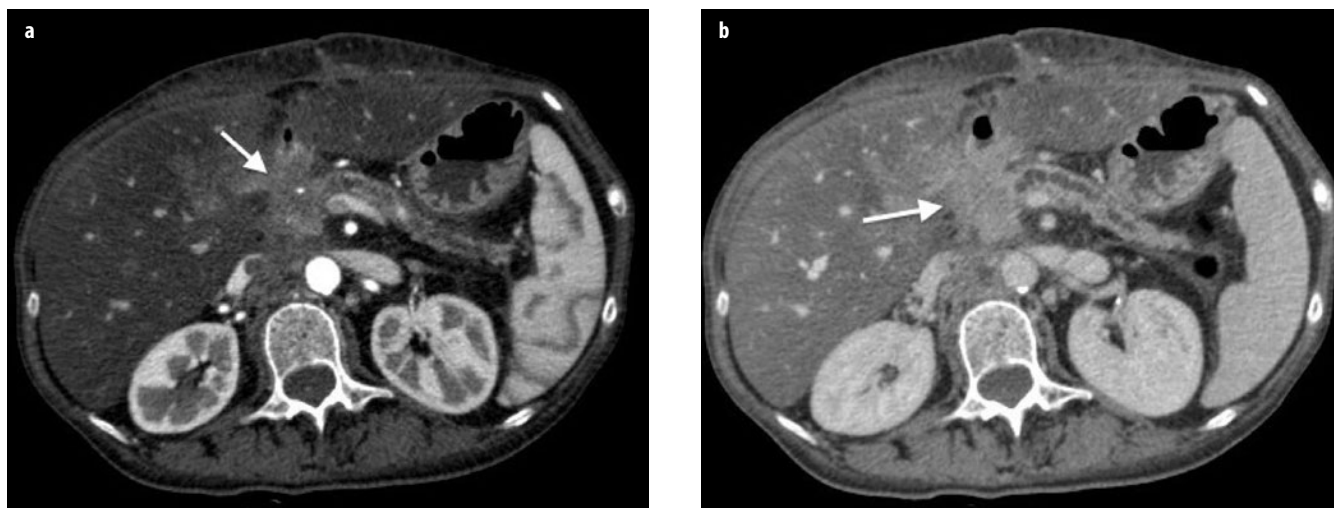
a, b. Adenocarcinoma of the head of the pancreas locally invasive. a Axial contrast-enhanced computed tomography (CE-CT) during the pancreatic phase shows a hypovascular focal pancreatic lesion of the head, responsible of infiltration of the main pancreatic duct, with obstructive chronic pancreatitis and infiltration of the peripancreatic fat (*arrow*). b Axial CE-CT during the portal-venous phase shows infiltration of the posterior peripancreatic fat (*arrow*)
